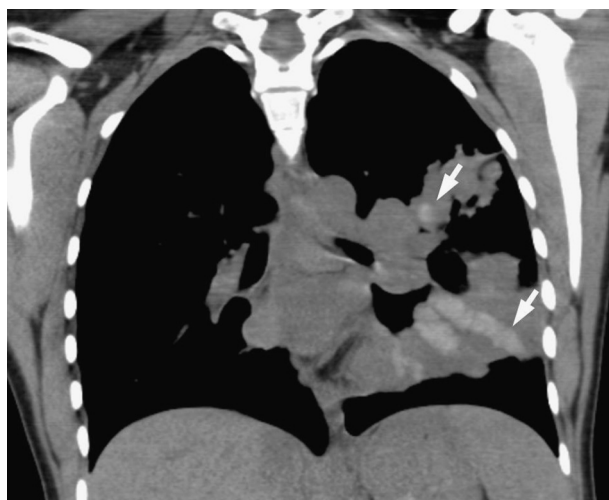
Coronal CT image of a patient with allergic bronchopulmonary aspergillosis (ABPA) demonstrating the hyperdense mucus sign. Arrows highlight high attenuation mucoid impaction within abnormally dilated bronchi.
